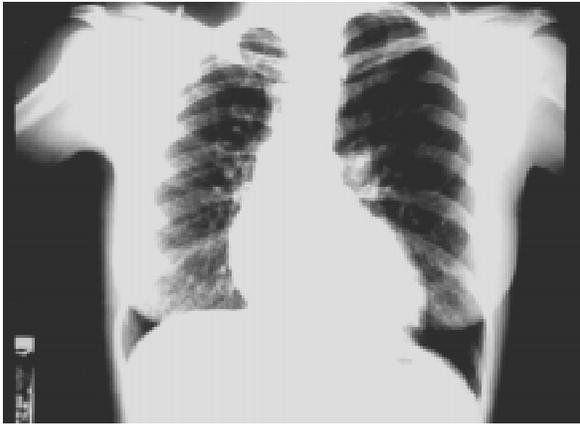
Chest PA roentgenogram. See text.
